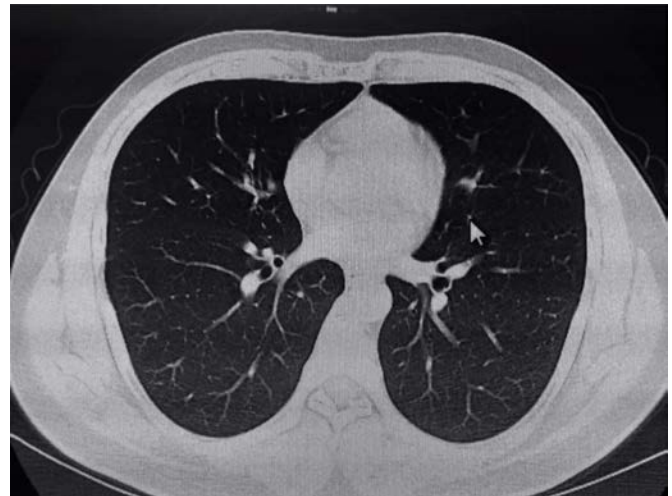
Thorax CT of patient with familial Mediterranean fever–COVID-19 showed normal finding.
